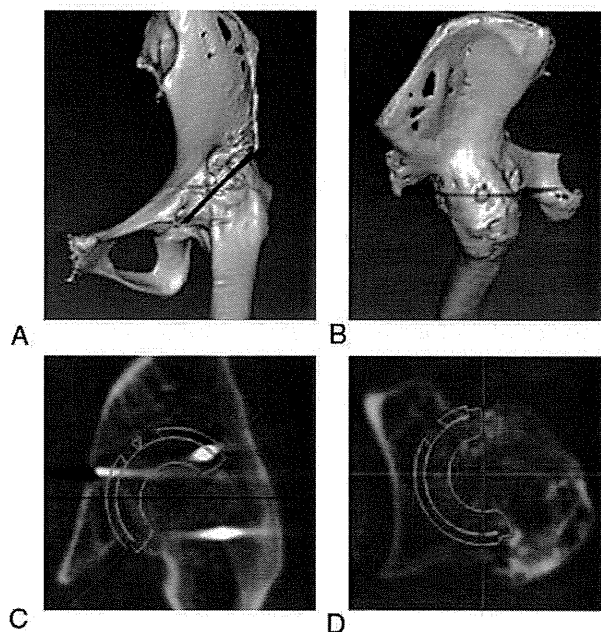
(A-D) Preoperative planning for the femoral neck osteotomy and (E and F) positioning of the socket during THA using the CT-based navigation system. The putative osteotomy (black plane) is indicated on the 3-dimensional anteroposterior (A) and lateral (B) views. The osteotomy line (purple line) is also shown on the 2-dimensional coronal (C) and horizontal (D) cross-sectional views. (E) Three-dimensional views in the coronal to pelvis plane, the frontal to midsagittal plane, and the frontal to base plane with the targeted socket shaded. (F) The 2-dimensional acetabular coronal, sagittal, and inlet section views are shown with the targeted socket shaded.
